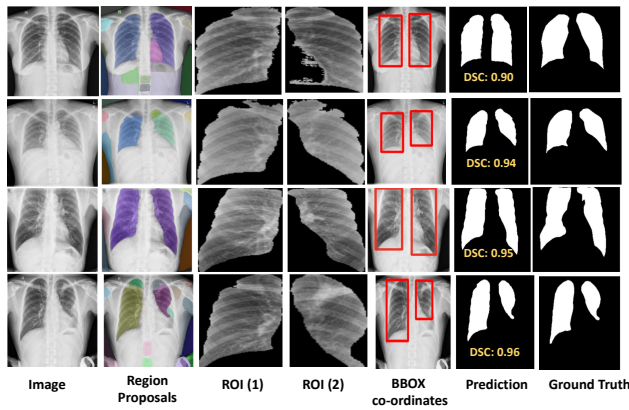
SaLIP qualitative results on X-ray labels and masks [19] dataset.
